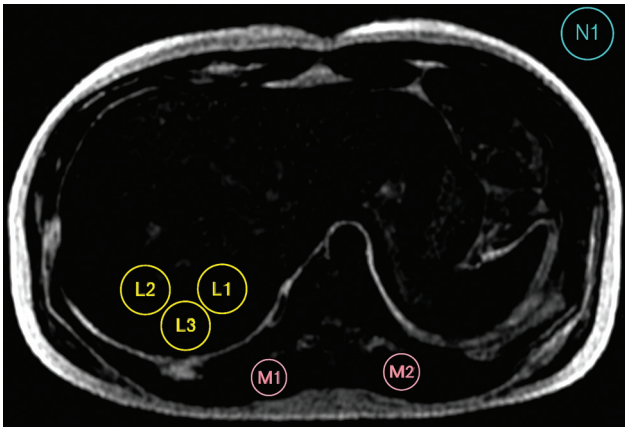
The placement of ROIs in MRI-PDFF (L1, L2, L3 for liver; M1, M2 for paraspinal muscle; N1 for background noise). MRI-PDFF, magnetic resonance imaging-proton density fat fraction; ROI, regions of interest.
